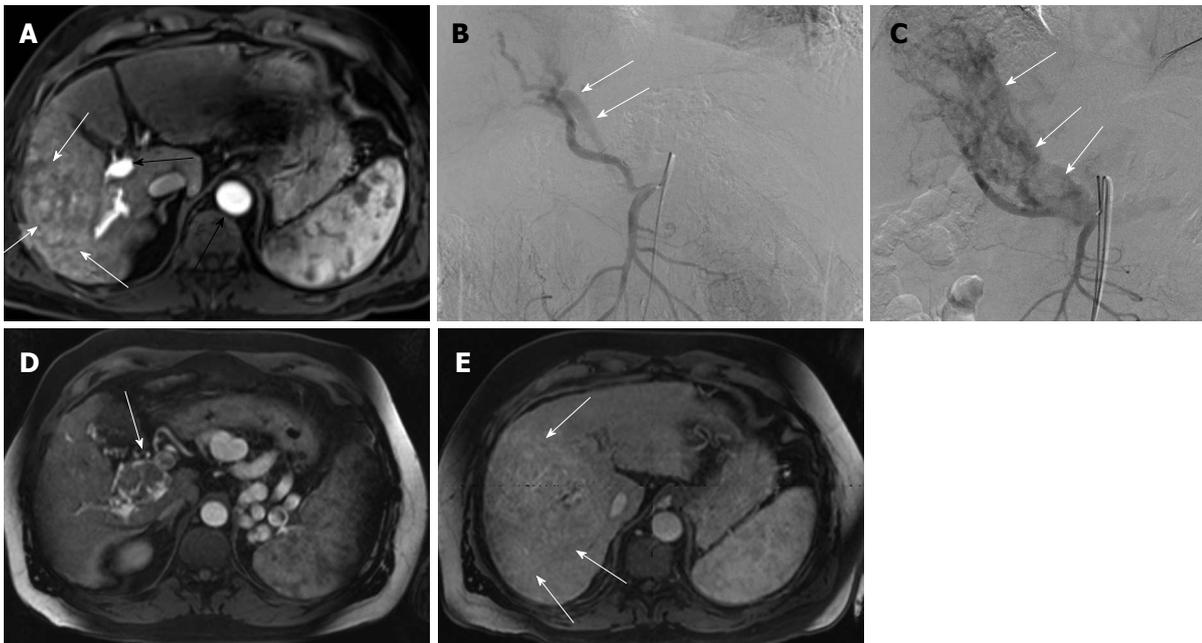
A 58-year-old male patient with alcoholic cirrhosis. A: Axial magnetic resonance imaging (MRI) T1 post contrast weighted image showing an ill defined mass in segments 5 and 6 (white arrows). Note enhancement of the portal vein (black arrow) in the arterial phase (black arrow head at the aorta) denoting an underlying arterioportal shunt; B: Digital subtraction angiography showing opacified portal vein (white arrows) during the arterial phase (APS) (white arrows); C: Digital subtraction angiography during the last (6th) transarterial chemoembolization (TACE) showing the APS with markedly dilated and partially thrombosed portal vein (white arrows); D, E: Axial MRI T1 post contrast after the last TACE showing tumor infiltration of the dilated main portal vein (white arrow in Figure 6D) and progression of the tumor size (> 20%) by MRI volumetry (white arrows in Figure 6E) (white arrows).
